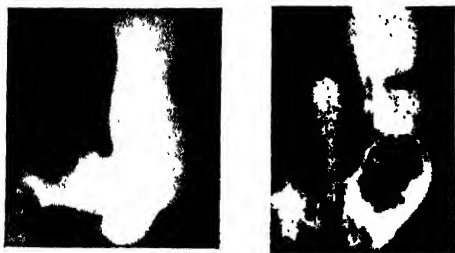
Barium-meal X-ray in carcinoma of (a) the antrum and (b) the body of the stomach.
